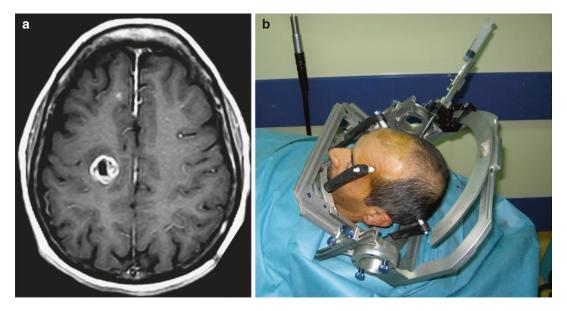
Axial cranial T1-weighted MRI following gadolinium administration revealing a Rolandic tuberculoma in the *right* side (a). Stereotacic-guided brain biopsy of the lesion in the same patient (Radionics* CRW* frame) (b)
